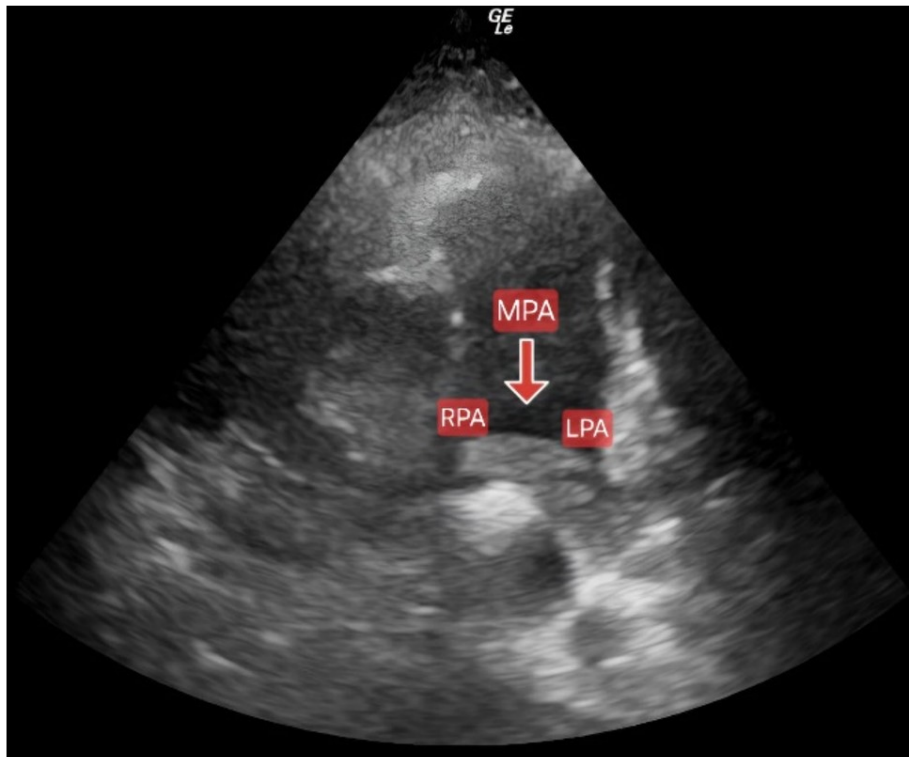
Echocardiography showing dilatation of the main pulmonary artery (MPA) and thrombus occluding the left pulmonary artery (LPA) with partial right pulmonary artery (RPA) obstruction.
